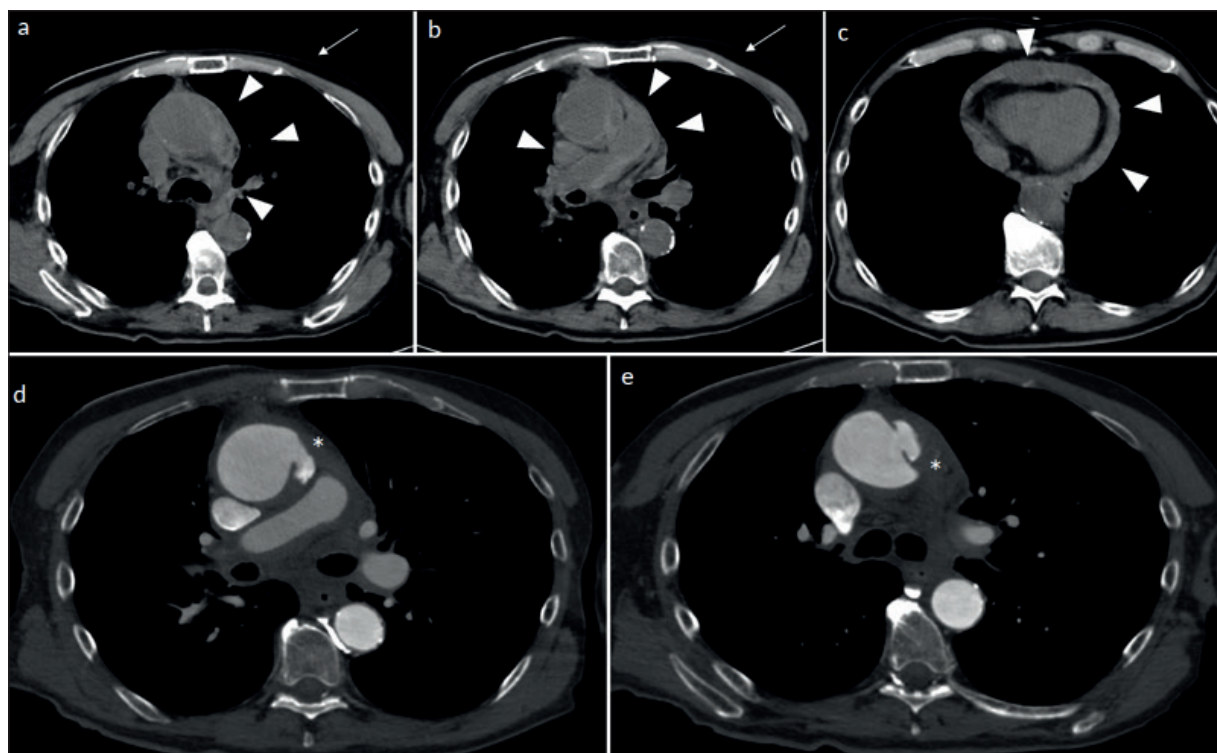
Patient with chest pain and hypotension. Basal CT scans (images a, b and c) show diffuse high-attenuated fluid among mediastinal structures and pericardial layers. CTA was acquired with a non-synchronized (thin white arrows) high-pitch technique (images d and e). CTA shows a complicated PAU with aortic rupture and pseudoaneurysms of the ascending aorta. High-pitch technique allows for good image quality. Abbreviations: CT: computed tomography; CTA: computed tomography angiography; PAU: penetrating aortic ulcer.
